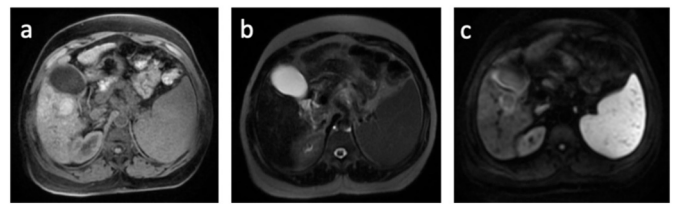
MRI of metastatic malignancy a) T1-weighted unenhanced b) T2-weighted c) DW-MRI. Case courtesy of Dr. Mohammad A. ElBeialy, [Radiopaedia.org](https://radiopaedia.org/cases/28994), rID: 28994. <https://radiopaedia.org/cases/28994>.
